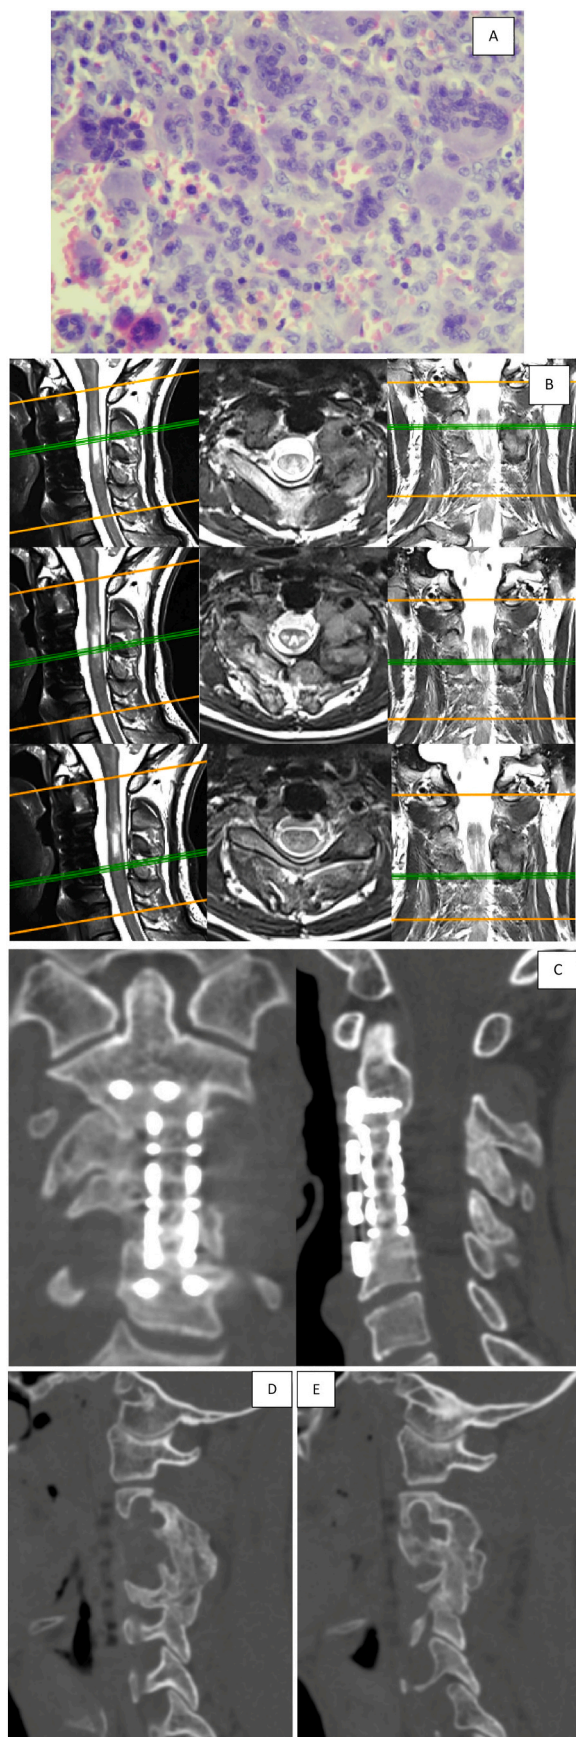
(A) Histopatologic Examination Show Giant Cell Tumor; (B) Post Operative Cervical MRI in V2-V4; (C) CT Scan Examination (fusion on anterior); (D) Fusion on Right Lateral Mass; (E) Fusion on Left Lateral Mass.
